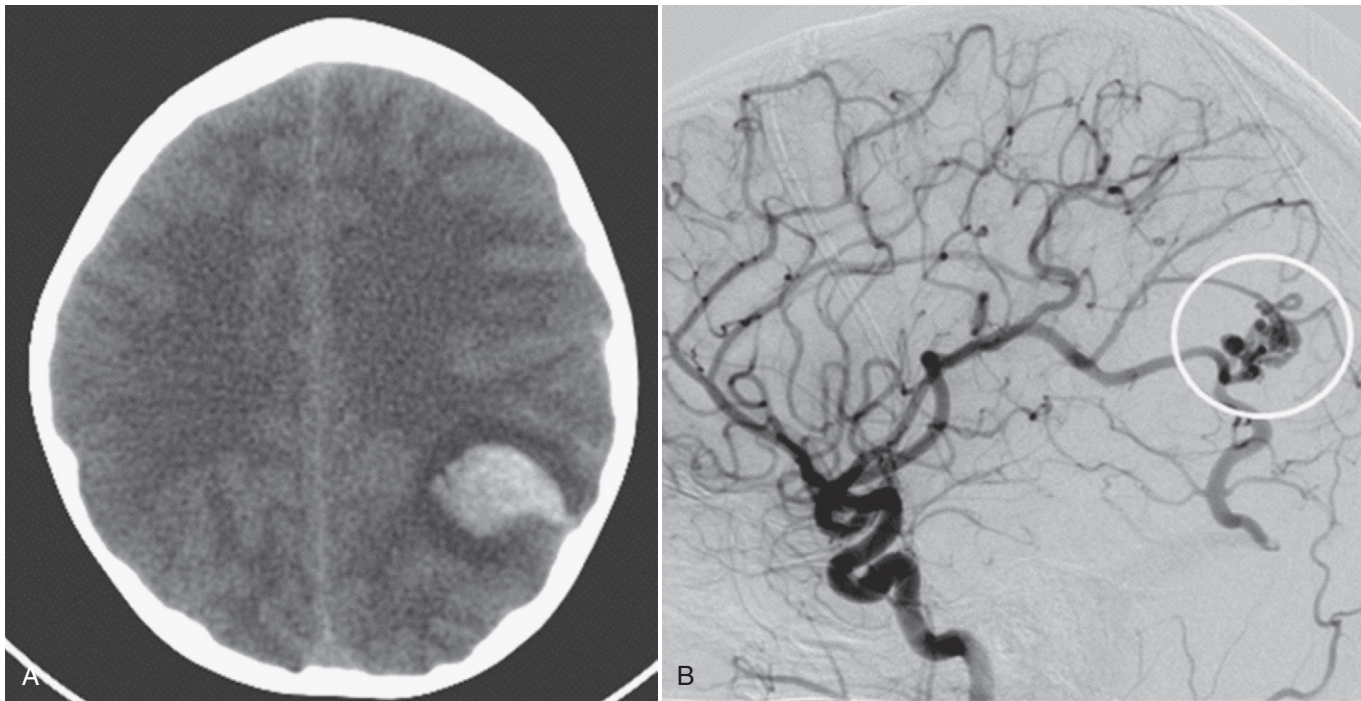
Severe headache, vomiting, and confusion develops in a 9-year-old healthy boy. A, A head CT scan shows left parietal parenchymal hemorrhage. B, An angiogram shows arteriovenous malformation (*circle*) being supplied by the left middle cerebral artery in nidus of hemorrhage.
